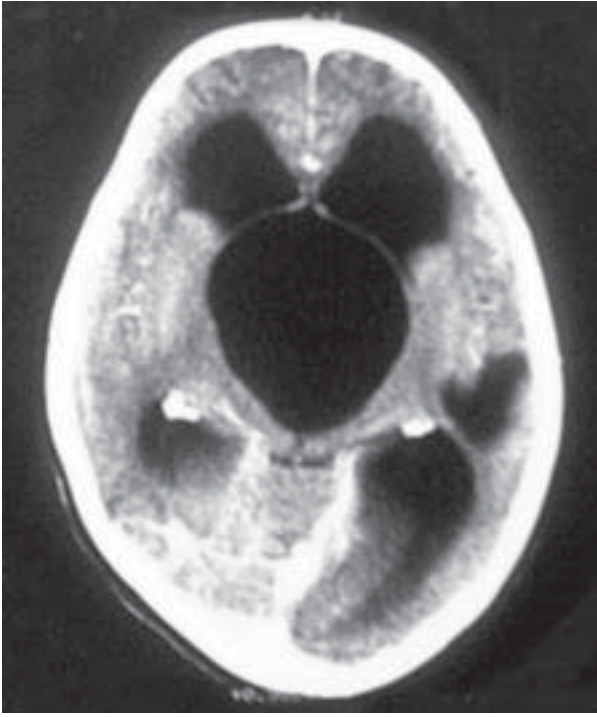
CT scan of head showing obstructive hydrocephalus secondary to aqueductal stenosis.
